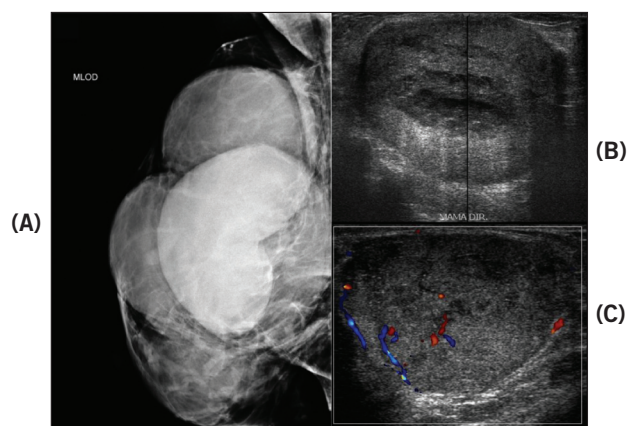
Imaging findings: mammographic mediolateral oblique view showing multiple regular hyperdense masses (A). Ultrasound of right breast: multiple circumscribed masses, heterogeneous, of well-defined contours (B) and hyper-flow of interior in color-flow Doppler imaging (C).
